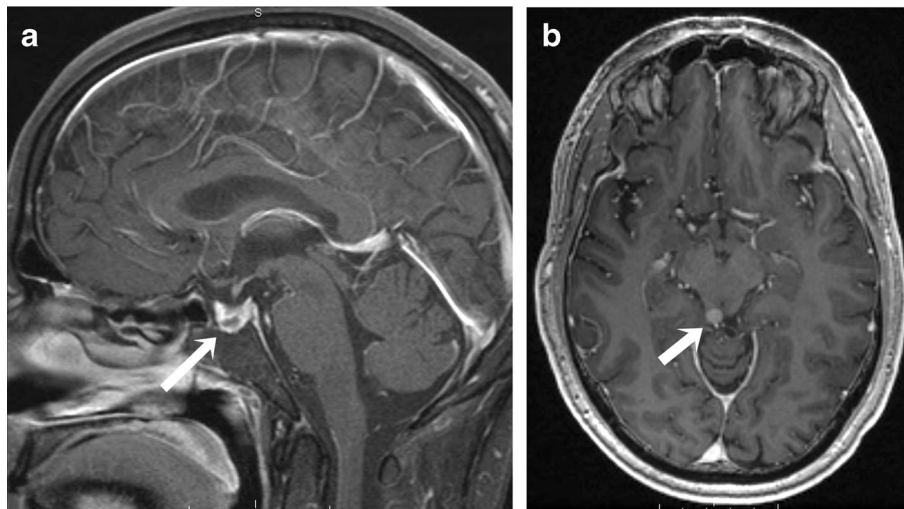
Post-contrast MRI revealed (a) a cystic pituitary adenoma (sagittal image, *white arrow*), as well as (b) an incidental finding of a small enhancing tectal mass (axial image, *white arrow*) thought to represent a tectal glioma.
